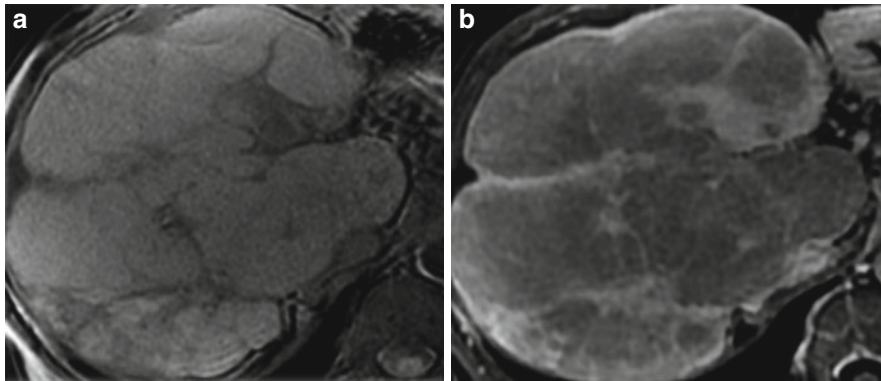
MR scans show liver fibrosis in a patient with advanced alcohol-induced cirrhosis. (a) Transverse T1-weighted breath-hold in-phase image demonstrates fibrotic septa and bridges as hypointense reticulations throughout the liver
